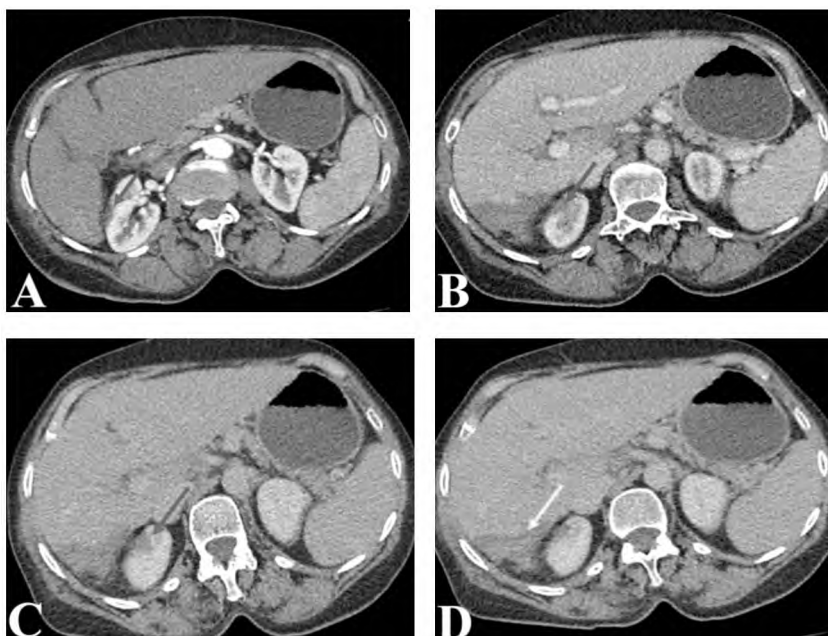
A female patient aged 70 years old with hepatitis C cirrhosis presented by right liver lobe HCC. (A,B,C&D): Triphasic CT abdomen (A): (Arterial), (B): (Portal), (C): (Delayed), (D) (Hypodense area) showing well-defined hypo-dense non-enhancing area in segment VI of the right liver lobe in all phases (Yellow arrow) with a hypo-dense area in the capsule and cortex of the right kidney (Red arrow).
